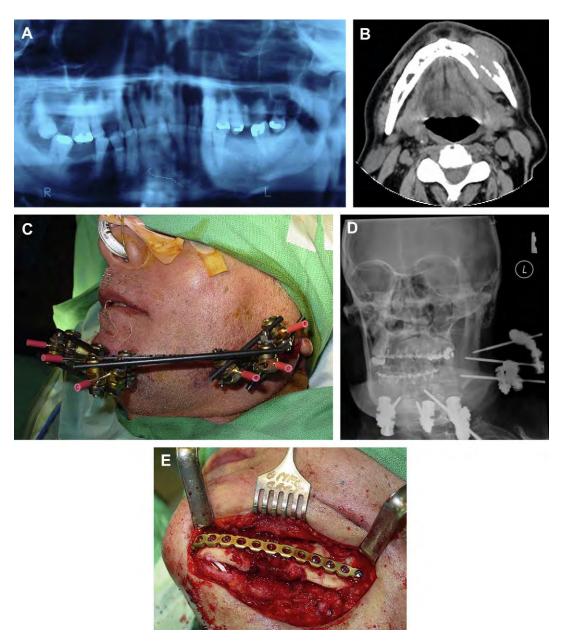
(A) A 56-year-old male patient with multiple myeloma of the left mandible and pathologic fracture visualized on the panoramic film. (B) Axial CT demonstrates the extent of the tumor with the fracture. (C) Pathologic fracture is stabilized with external fixation until radiotherapy is completed. (D) Postero-anterior cephalogram demonstrates pin placement. Note that carbon rods are not radiopaque. (E) Debridement of the fracture, debulking of the tumor, and reconstruction plate applied at later stage.
